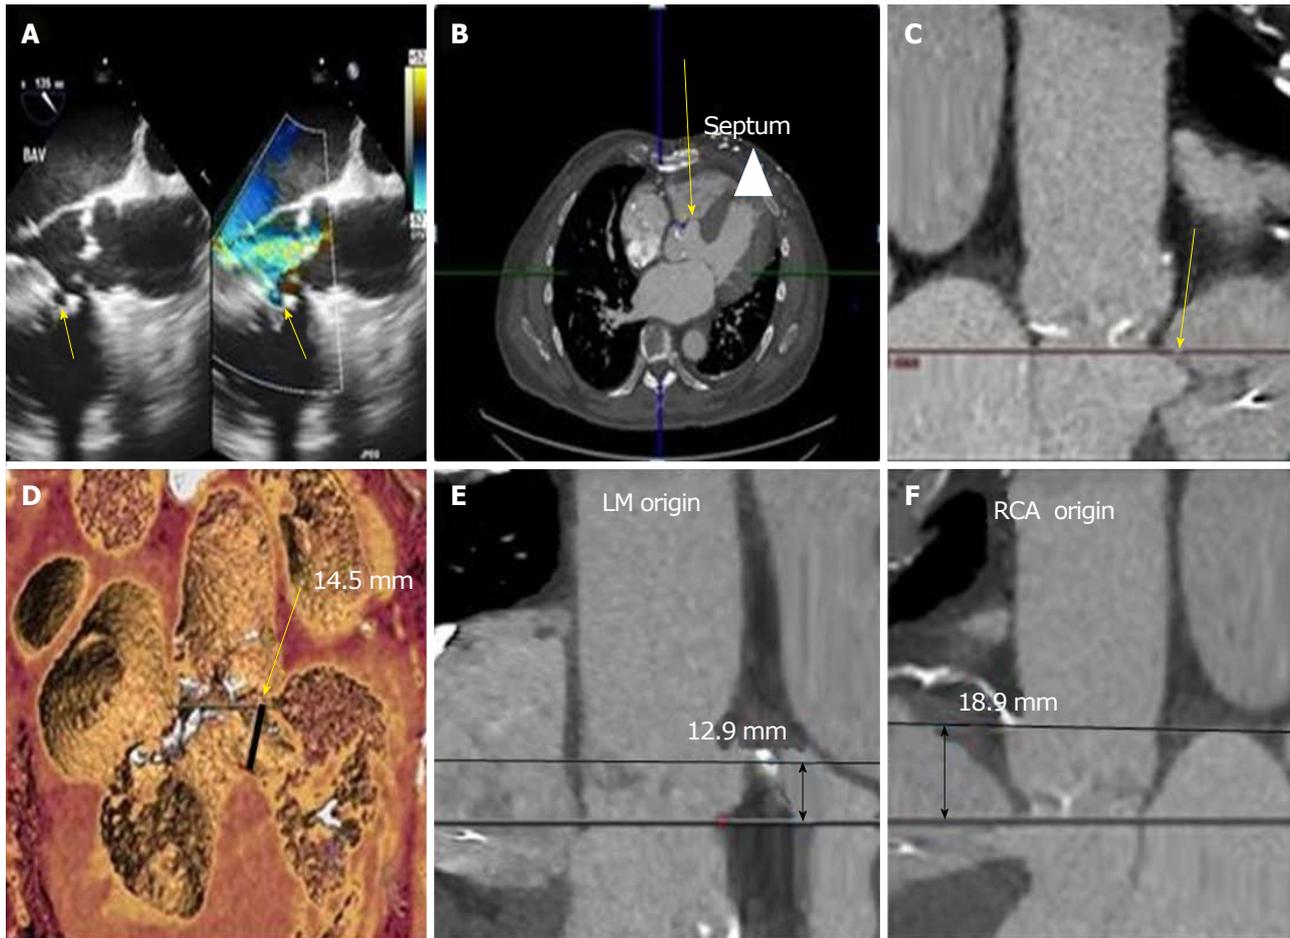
Assessment of the calcific aortic valve and interventricular septal aneurysm prior to transcatheter aortic valve replacement. A: Transesophageal echocardiography shows a perimembranous ventricular septal aneurysm (arrow) and severe calcific stenotic aortic valve with moderate aortic regurgitation; B: Cardiac computer tomography (CT) findings confirmed the focal interventricular septal aneurysm (arrow) below the aortic annulus in the transverse view along the membranous septum with left ventricular outflow tract extension (arrowhead); C: Cardiac CT in coronal view showing interventricular septal aneurysm (arrow) below the annulus; D: The dimension at the neck of septal aneurysm (arrow) was 14.5 mm on 3-D reconstructed CT image; E and F: The aortic annulus to left main ostium distance was 12.9 mm and annulus to right coronary ostium distance was 18.9 mm.
